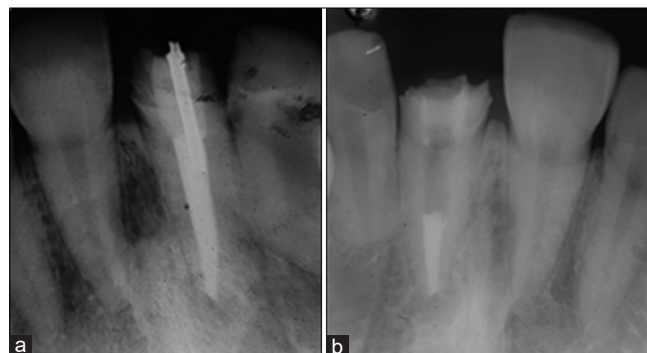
a) Intraoral Radiograph showing an Post, b) After removal of Post
